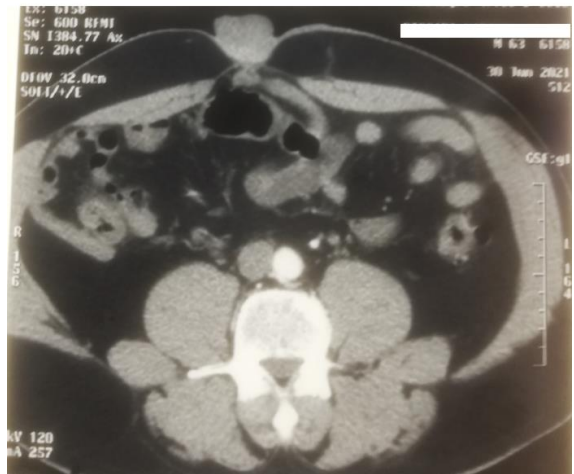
CT scan of the abdomen showing sister Mary Joseph nodule measuring 29x28 mm (white arrow)
